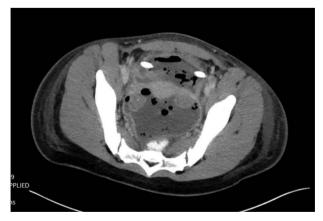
CT findings of pelvic fluid collection.
